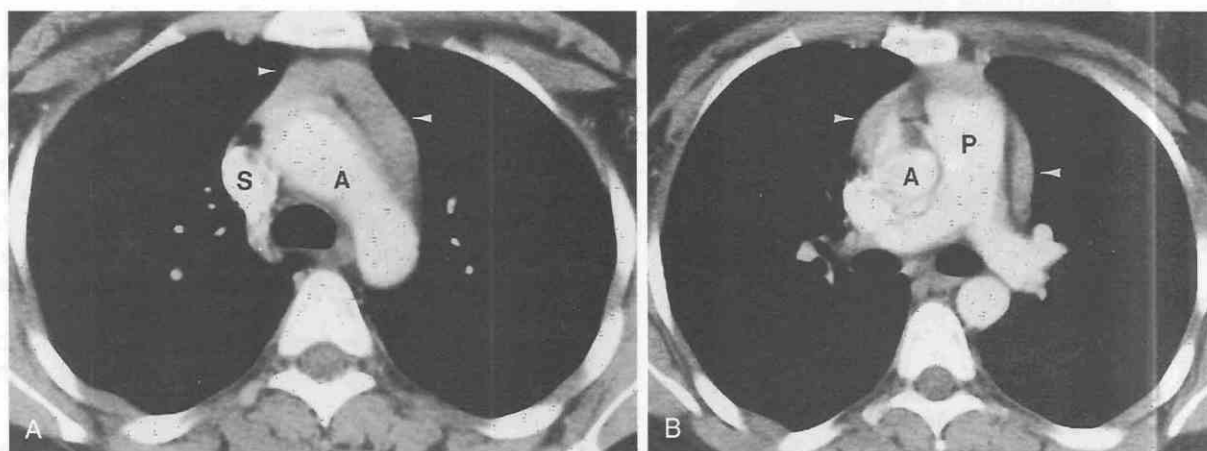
Normal thymus gland in a 17-year-old girl. *A* and *B*, Contrast-enhanced CT shows normal thymus gland in anterior mediastinum (arrowheads). Homogeneous attenuation, smooth contours, and close association of lobes to vascular structures in the anterior mediastinum can be seen. A, aorta; P, main pulmonary artery; S, superior vena cava.
